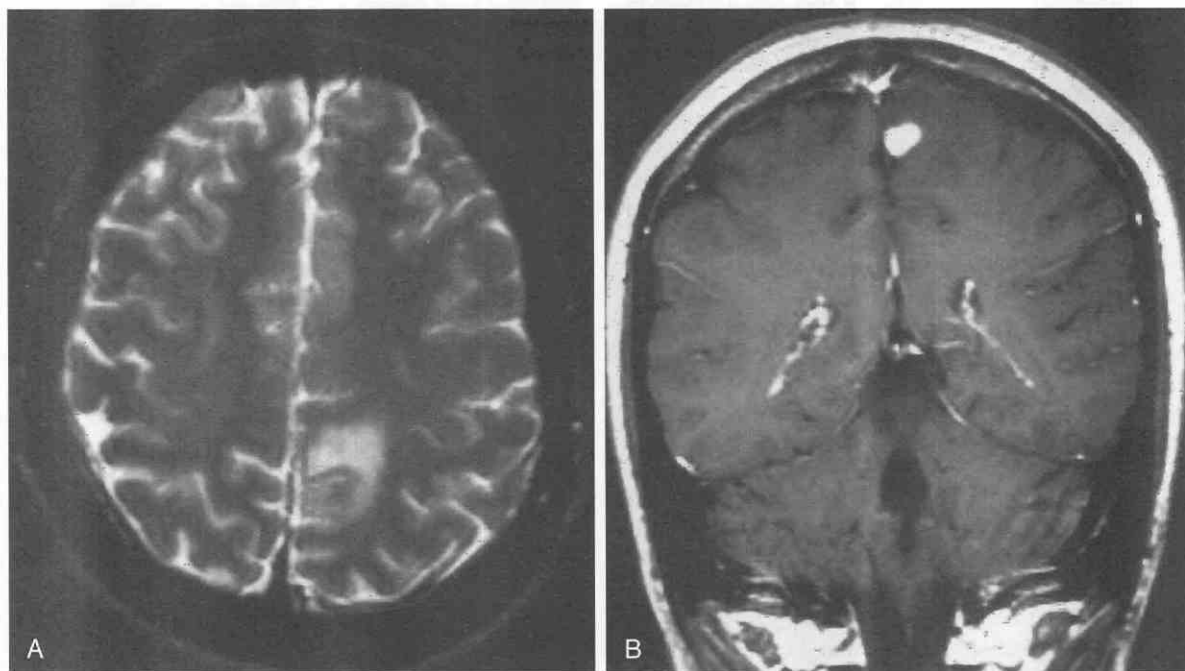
Early cerebritis. A, T2-weighted image demonstrates a low-signal-intensity focus with surrounding high-signal-intensity edema. B, Gadolinium-enhanced MRI study shows nodular enhancement with surrounding edema.
